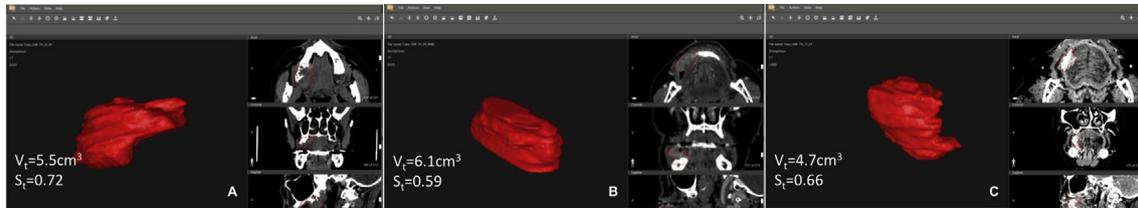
CT scans of examples of segmented tumors, obtained using D2P™ software, for different anatomical regions: a) upper alveolar gingiva; b) lower alveolar gingiva; c) tongue. V_t = tumor volume; S_t = tumor sphericity.
